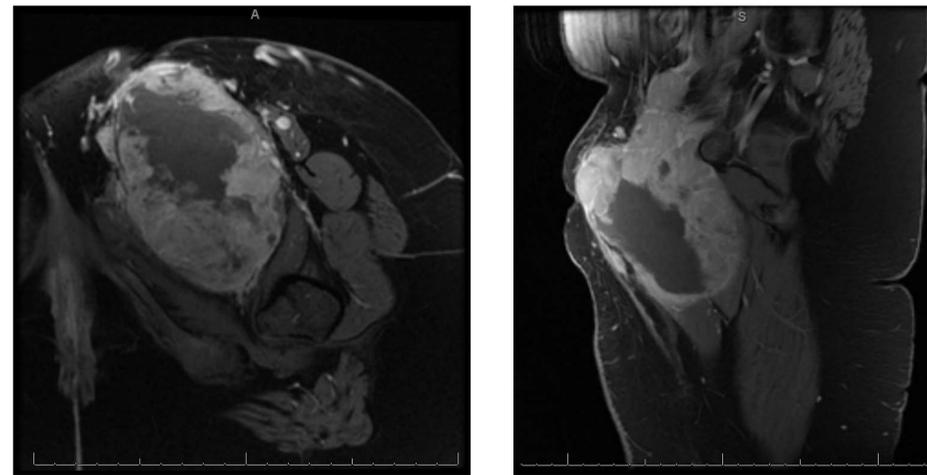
T2 MRI of the pelvis and thigh showing a heterogeneous mass measuring 15 x 10 x 8 cm in the left thigh with extension into the pelvis.
